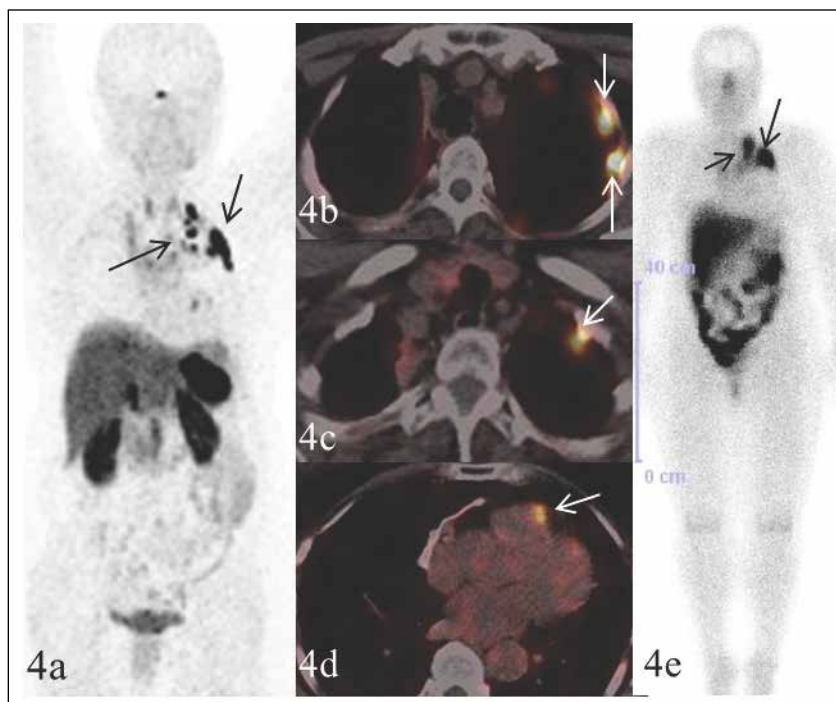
Maximum intensity projection image (A) of ^{68}Ga DOTATOC positron emission tomography/computed tomography study performed in May 2014, showing multiple tracer foci in the mediastinum, corresponding to pleural and pericardial metastatic deposits on axial fused positron emission tomography/computed tomography images (B-D). A post- ^{177}Lu DOTATATE therapy (June 2014) scan showed tracer uptake in pleural and pericardial metastases.
